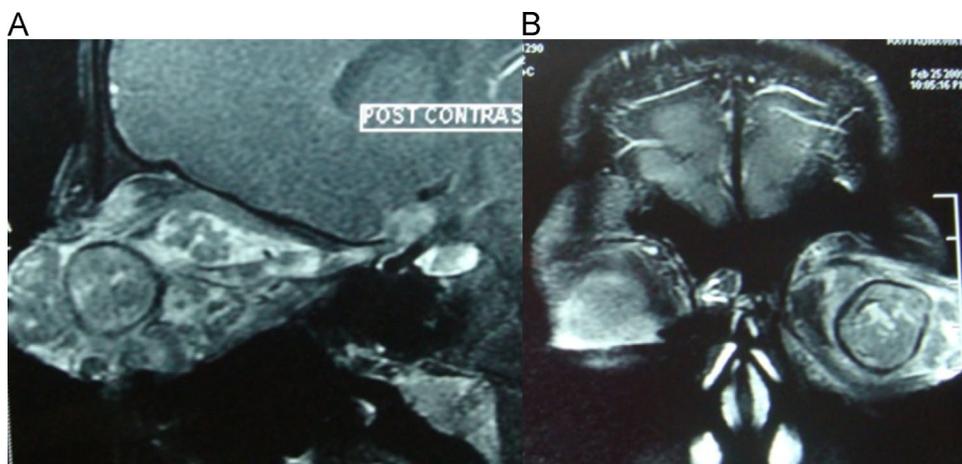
A, Sagittal section of post-contrast magnetic resonance imaging (MRI) scan showing a heterogeneous enhancing mass occupying the entire left orbit with involvement of the optic nerve up to the optic chiasma. B, MRI, coronal section showing a staphylocomatous globe filled with an intraocular mass with extrascleral extension in the orbit.
